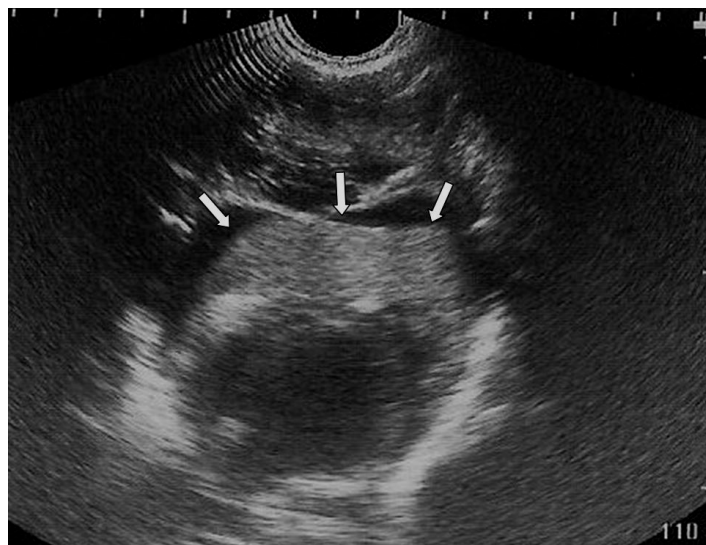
2D echocardiography confirming the presence of a large clot sitting on top of the right atrium as indicated by the white arrows.
